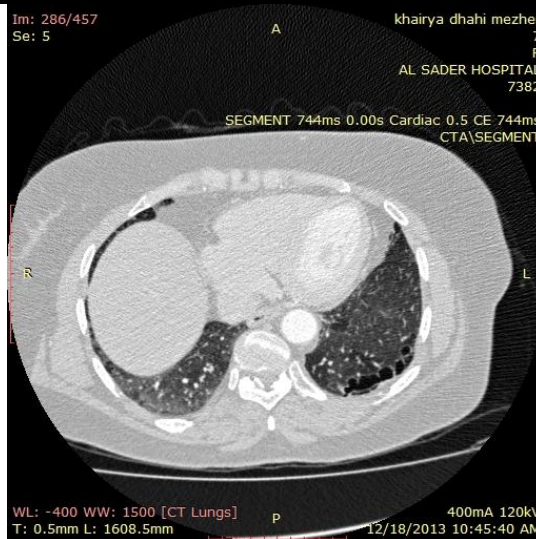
Emphysematous changes incidentally found in 48 years old woman who was referred for coronary CT angiography for evaluation of chest pain and dyspnea.
